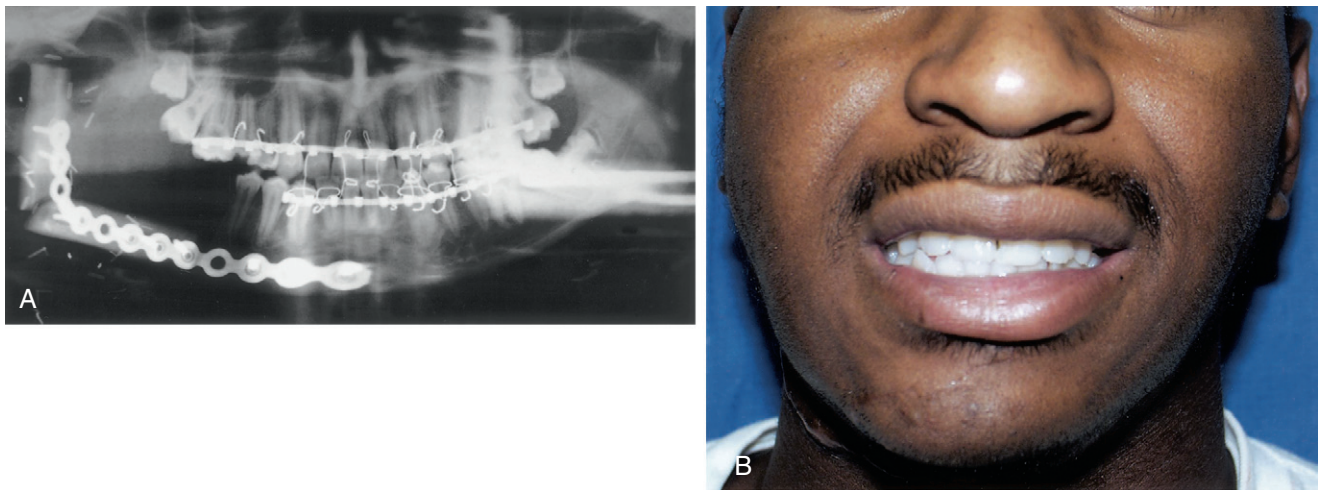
A, Immediate postoperative radiograph of a 35-year-old man after resection of an osteosarcoma of the mandibular ramus and reconstruction with a fibular osseocutaneous free flap. B, At 6 months postoperatively, the patient's dental occlusion has been preserved, along with excellent facial contour.
